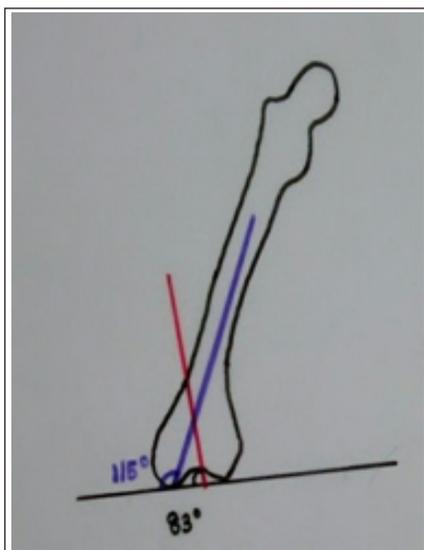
Xray shows varus deformity in the knee arising from distal femur
